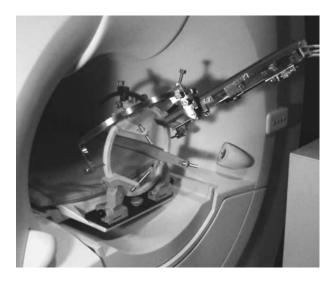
Computer assisted stereotactic guiding system and intraoperative MRI (Department of Stereotaxy and Functional Neurosurgery, Cologne University, Cologne, Germany)
